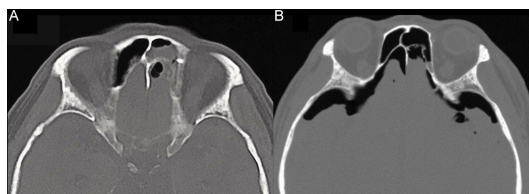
(A) CT with axial view on the day of trauma—small pneumocephalus around the tip of left frontal lobe. (B) CT with axial view 1 day after trauma. 'Mount Fuji sign'—the amount of air between the tips of the frontal lobes increased progressively.
